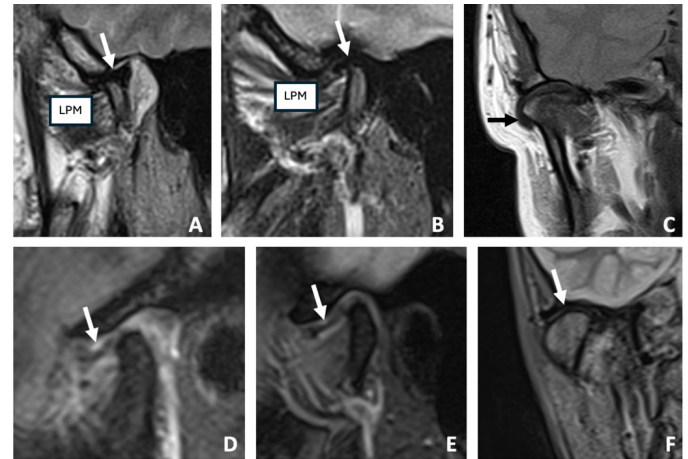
A and B: T2-weighted images in open (A) and closed (B) mouth positions, depicting normal disc position and lateral pterygoid muscle (LPM). C: Proton Density Turbo Spin Echo (PD TSE) image showing lateral disc displacement. D and E: T2-weighted images in open (D) and closed (E) mouth positions displaying anterior disc displacement. F: T2-weighted Spin Echo (SE) with Short Tau Inversion Recovery (STIR) sequence demonstrating the normal position of the disk in the coronal plane.
